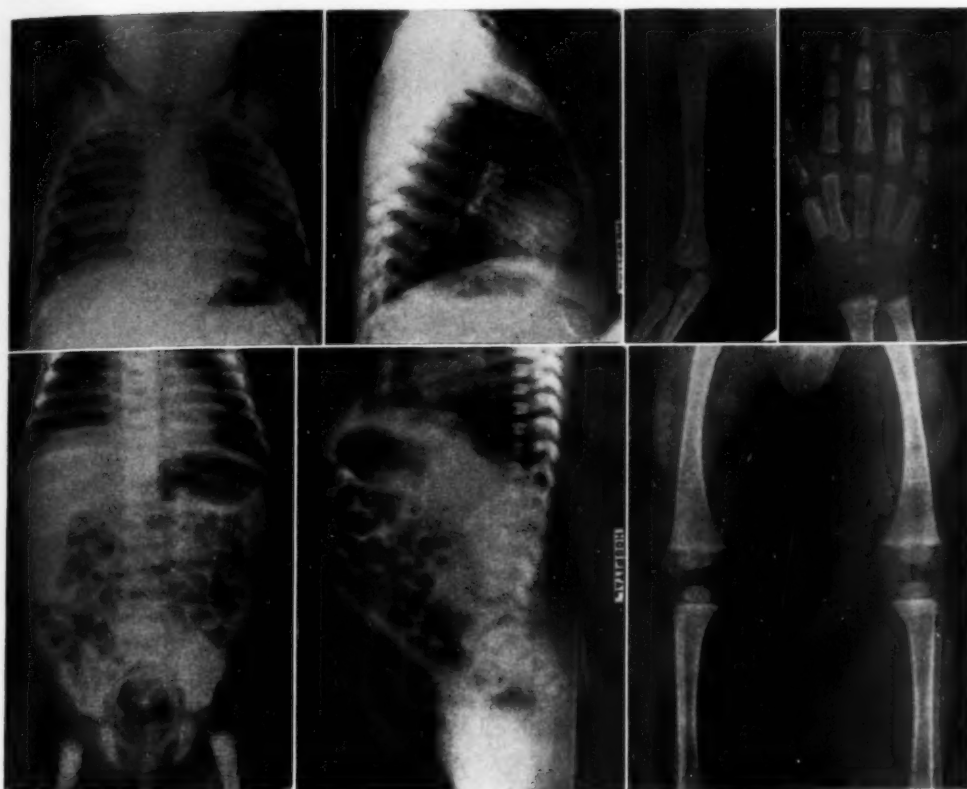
Radiographs of children bound to the "board" showing the radiolucency of the "board," the edge artefact, and the satisfactory positioning of the patient made possible by the use of the device.
